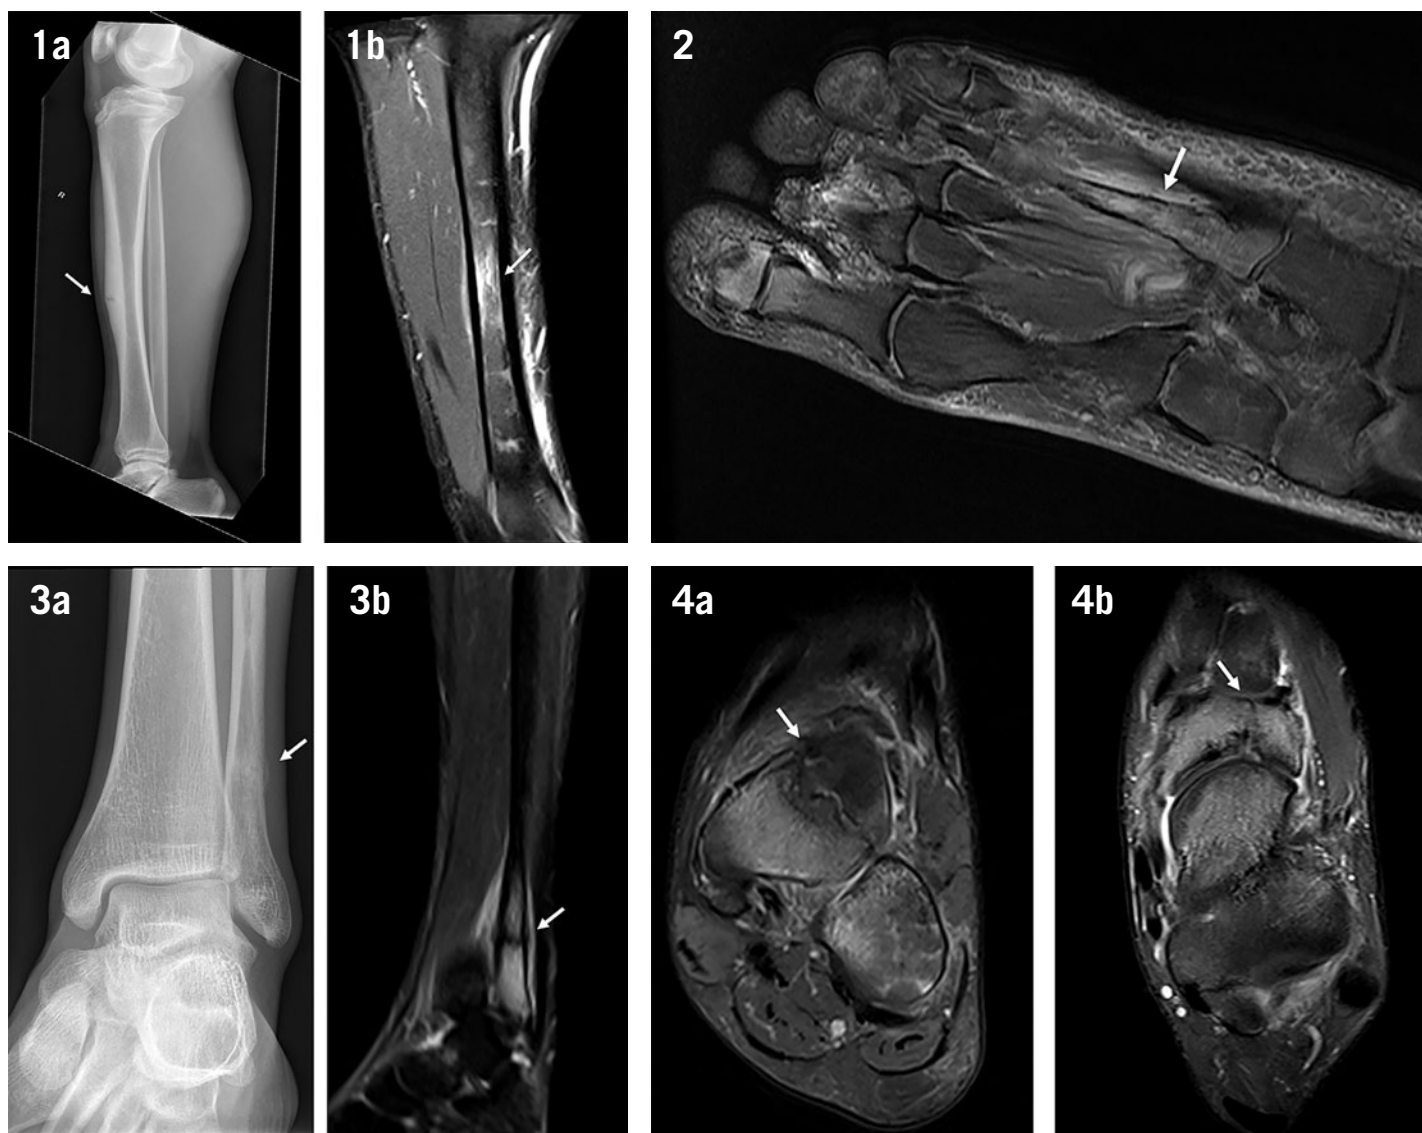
Tibial stress fracture of the anterior cortex. (a) Conventional sagittal radiograph showing endosteal thickening, periosteal reaction and an incomplete fracture line through the anterior tibial cortex (b) Coronal T2-weighted image demonstrating periosteal and bone marrow edema.
